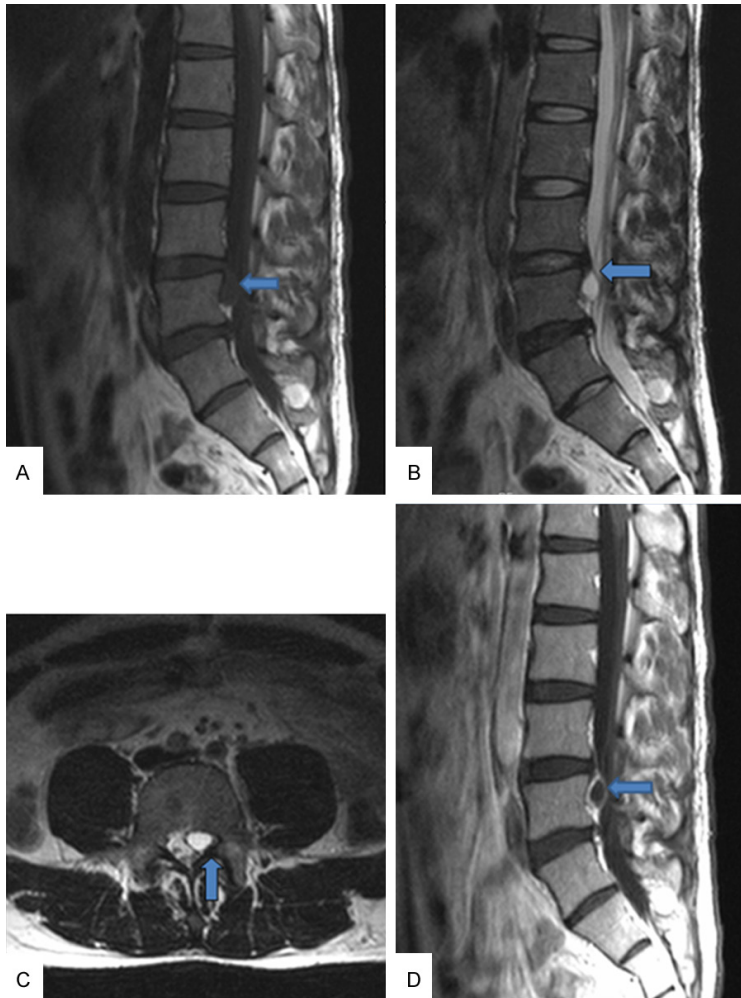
Thirty-seven-year-old man with left lower limb radiating pain. A. Sagittal T1-weighted image, the cyst displayed a low signal intensity, communicated with the L4/5 disc by a pedicle. B. Sagittal T2-weighted image, the cyst displayed a high signal intensity. C. Axial T2-weighted image, the cyst pressed the left L5 nerve root. D. Contrast-enhanced MRI, a circular enhancement appeared at the cyst site.
